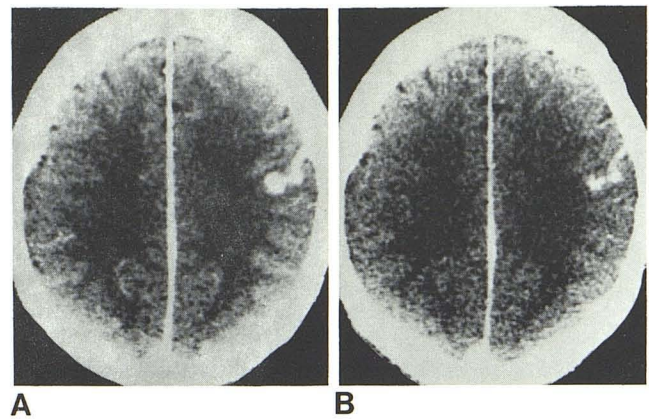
Category 3 lesion. A, Immediate contrast CT. Left convexity serpiginous density shown to be arteriovenous malformation at angiography. B, Delayed high dose CT. True size of lesion seen. Size no longer artifactually enlarged by higher CT units seen on immediate contrast scans.
